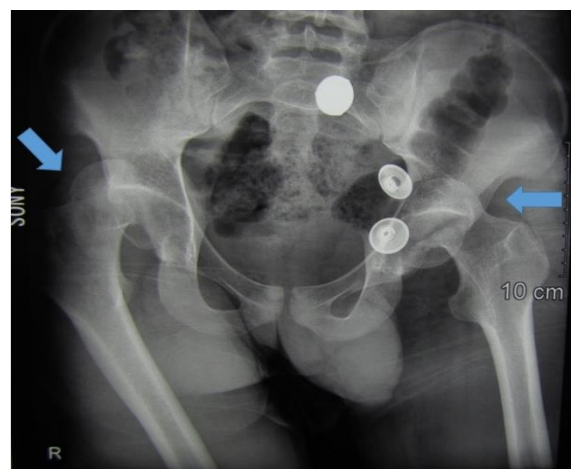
Pre-reduction pelvic radiograph: Anteroposterior (AP) view of the pelvis, showing posterosuperior dislocation in the right hip and anterior dislocation in the left side (arrows)
